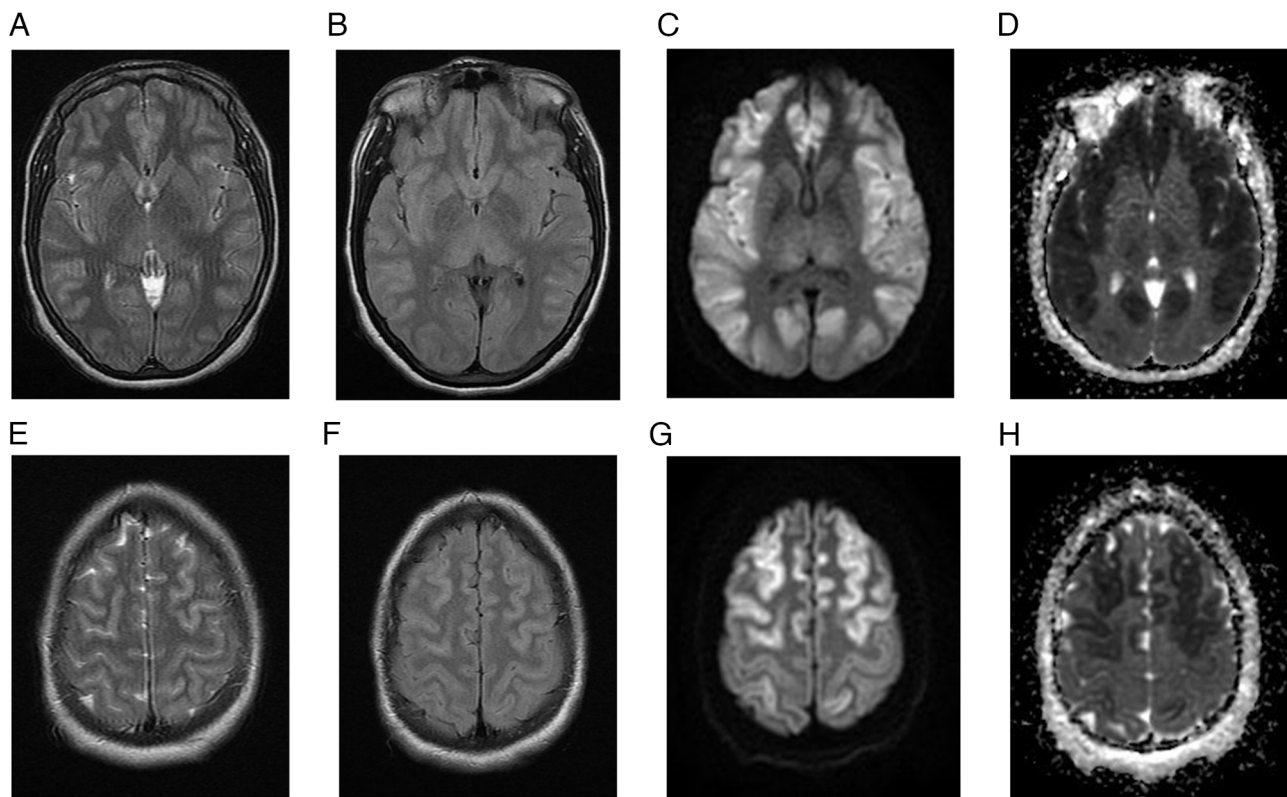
MRI brain scan for case 4. (A) T2-weighted MRI, (B) FLAIR, (C) DWI and (D) ADC map demonstrating symmetric cortical swelling with high T2 and FLAIR signal intensities involving the bilateral insular cortex, frontal lobes, temporal lobes, parietal lobes and cingulate gyri. The bilateral occipital lobes are spared. Foci of high T2 and FLAIR signal intensities are observed in the right anterior thalamus, left globus pallidus and splenium of the corpus callosum, with corresponding diffusion restriction, likely representing ischemic insults. At the level of the vertex, (E) T2-weighted MRI, (F) FLAIR, (G) DWI and (H) ADC map demonstrating asymmetric cortical swelling with high T2 and FLAIR signal intensities involving the frontal and parietal lobes, with corresponding restricted diffusion. The bilateral peri-rolandic regions are spared. MRI, magnetic resonance imaging; FLAIR, fluid attenuated inversion recovery; DWI, diffusion-weighted imaging; ADC, apparent diffusion coefficient.
